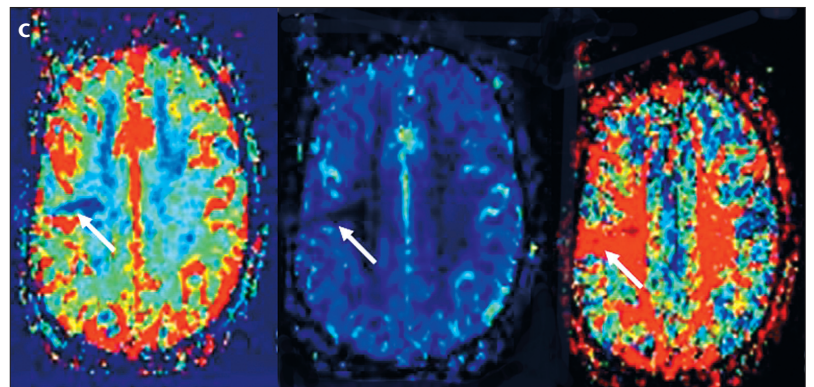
a-c. Patient 10 with a small ischemic area. Trace image of diffusion-weighted MR imaging on the left and apparent diffusion coefficient (ADC) map on the right show the right frontal acute ischemic lesion (a). Top (b) rCBV, rCBF, and MTT maps are from our homemade software. Bottom (c) maps, in the same order as above, are from the commercial software. Although our program furnished valuable information about the ischemic area, field definition was better in the maps produced with the commercial program. However, with respect to artifacts in the surrounding area, the results of our product were better.
